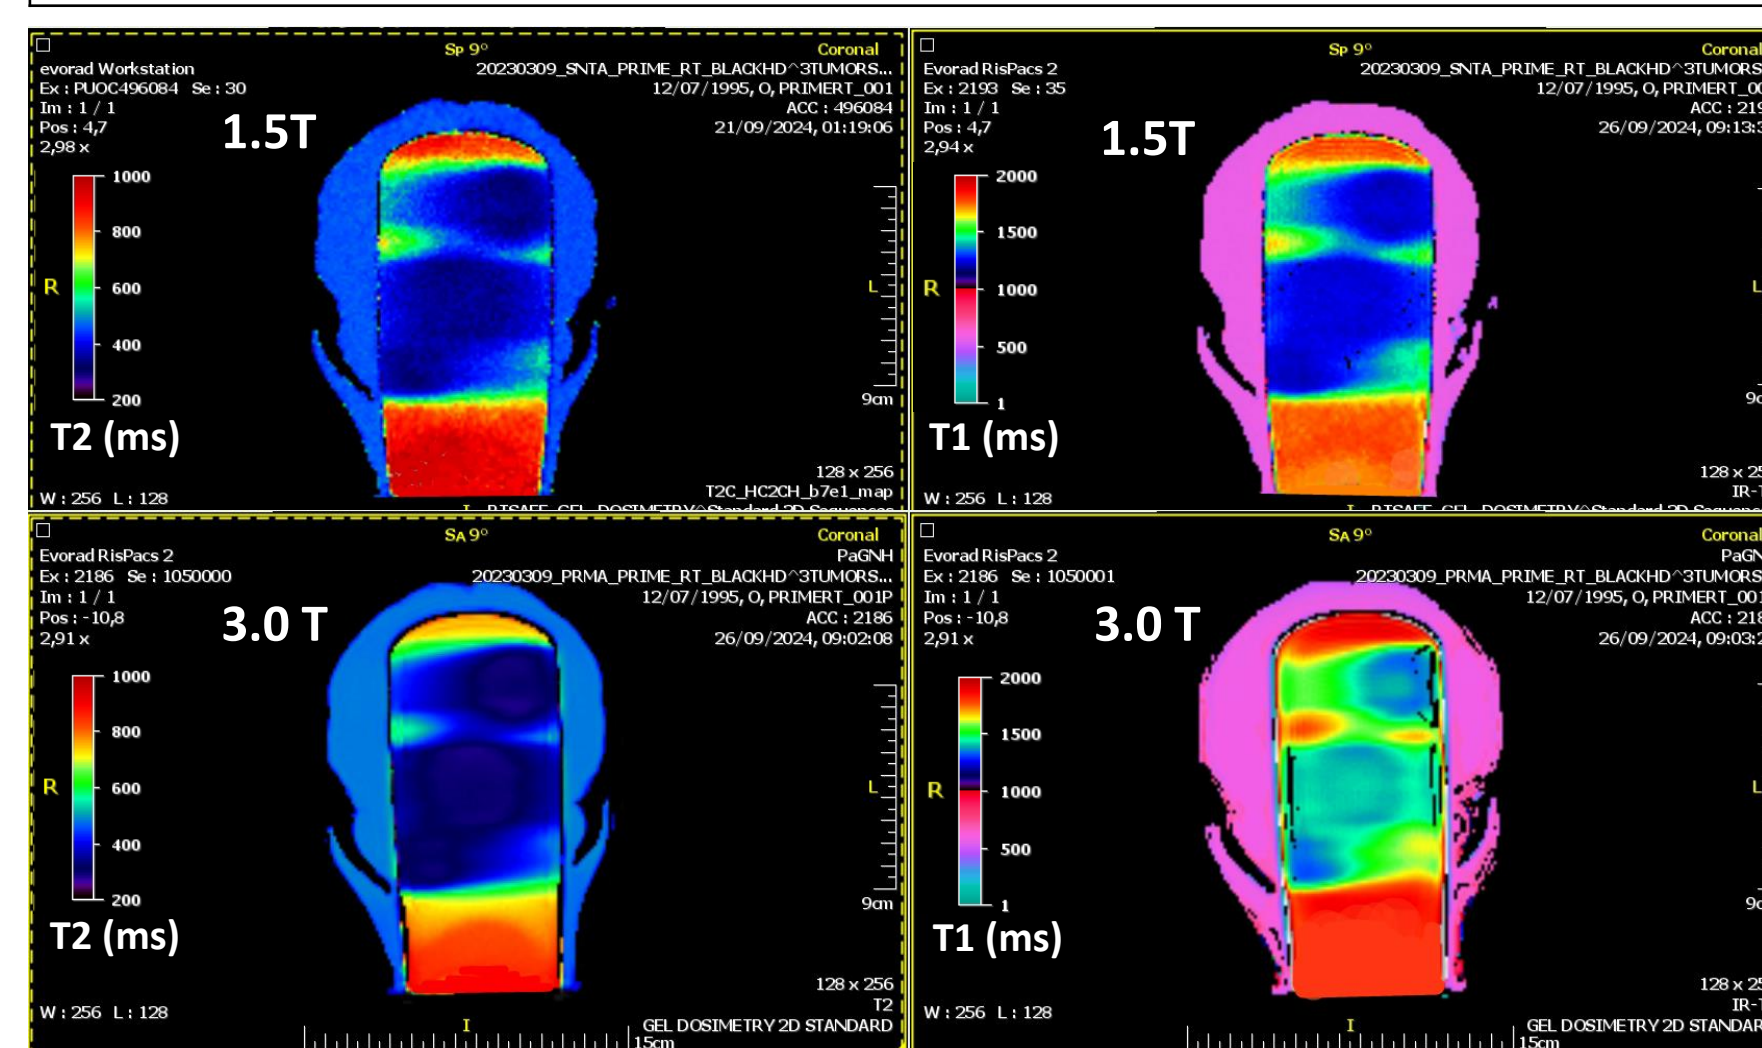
Color T2 and T1 parametric maps in 1.5T and 3.0T clinical MRI systems of 3 irradiated tumors each of which received a dose of 20 Gy. Noticeable T2 and T1 differences on the irradiated and non-irradiated areas between the two different static magnetic fields.
